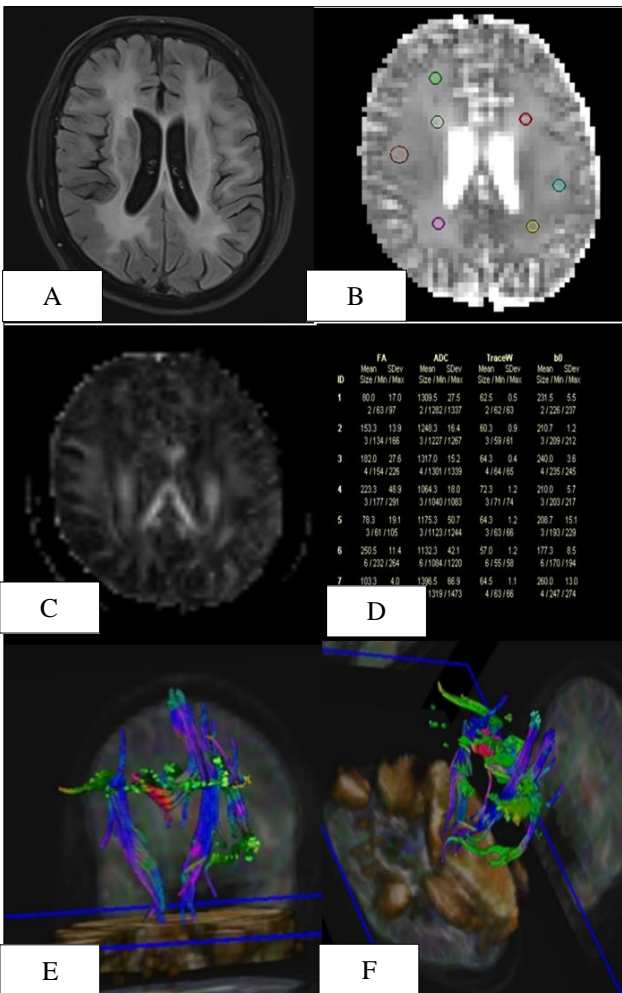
PML associated with HIV encephalopathy. Axial FLAIR (A) image of brain showing bilateral extensive white matter involvement with involvement of subcortical U fibres. Lesions appear dark on FA map (B) and bright on ADC map (C). (D) FA and ADC chart. 3D tractography images (E,F) white matter fibre loss in bilateral corticospinal tract (right > left).
